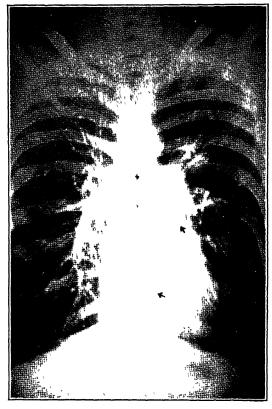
Contrast roentgenogram Three seconds after the beginning of injection Normal, aged 20. The right chambers of the heart, the pulmonic conus, and the entire pulmonary arterial tree are filled with diodrast. The interventricular septum is indicated by the lower arrow, and the left cusp of the pulmonic valve by the upper arrow. The right branch of the pulmonary artery is bracketed by darts (Robb and Steinberg, Am. J. Roentgenol.)
